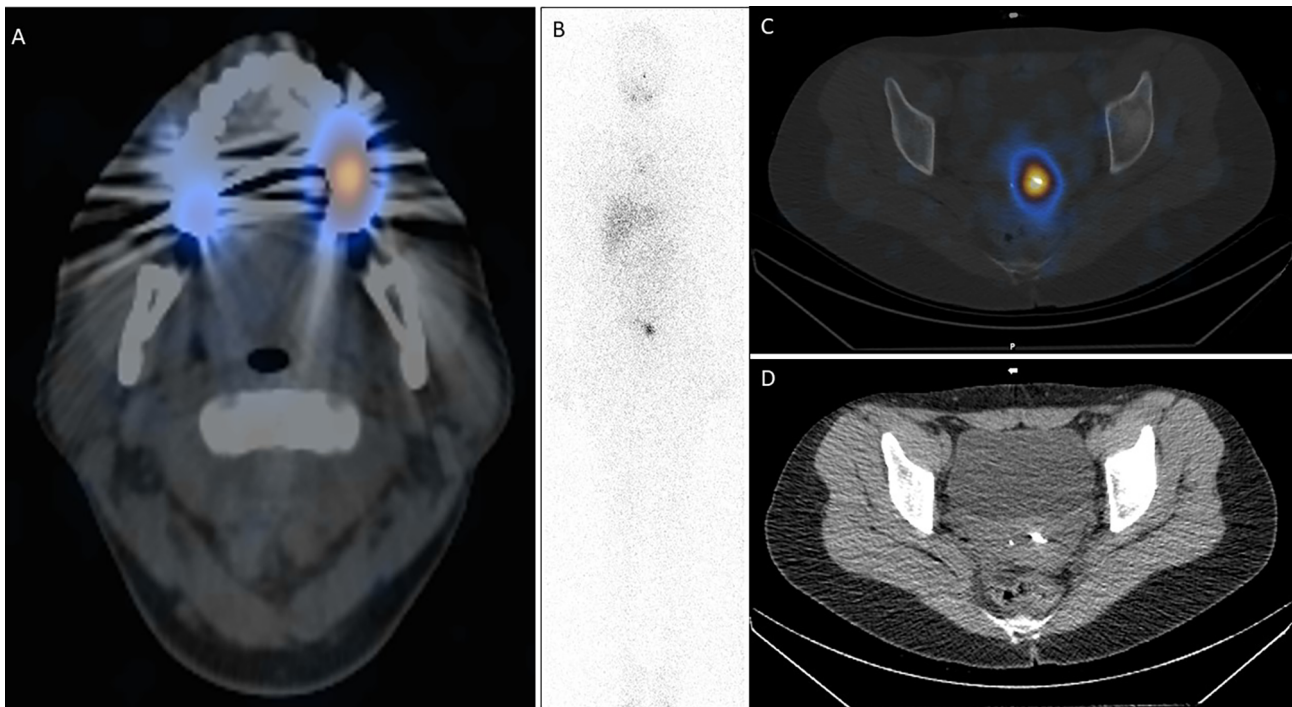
I-131 retention by direct chemical binding to metallic foreign bodies. a SPECT/CT with RAI retention in dental amalgam. b RAI-WBC, c SPECT/CT, and d CT showing uptake by copper intrauterine device
